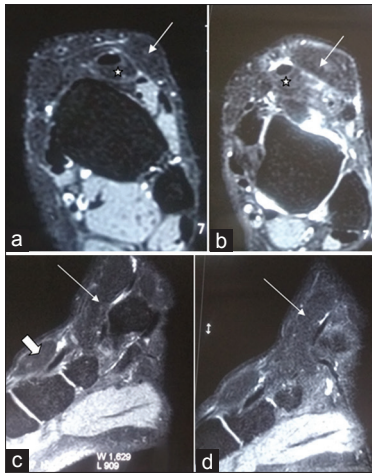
Axial (a and b) and sagittal (c and d) fat-saturated magnetic resonance images of the left ankle joint showing suppression of signal in all the previously described lesions, suggesting fat component. The hyperintense lesion in tibialis anterior tendon sheath shows loss of signal on fat saturation which is suggestive of tendon sheath lipoma (star ☆). Loss of signal is also seen in thickened superficial peroneal nerve (arrow) suggesting fatty infiltration. Subcutaneous swelling also shows loss of signal on fat-saturated images verifying it's a lipoma (black arrow)
